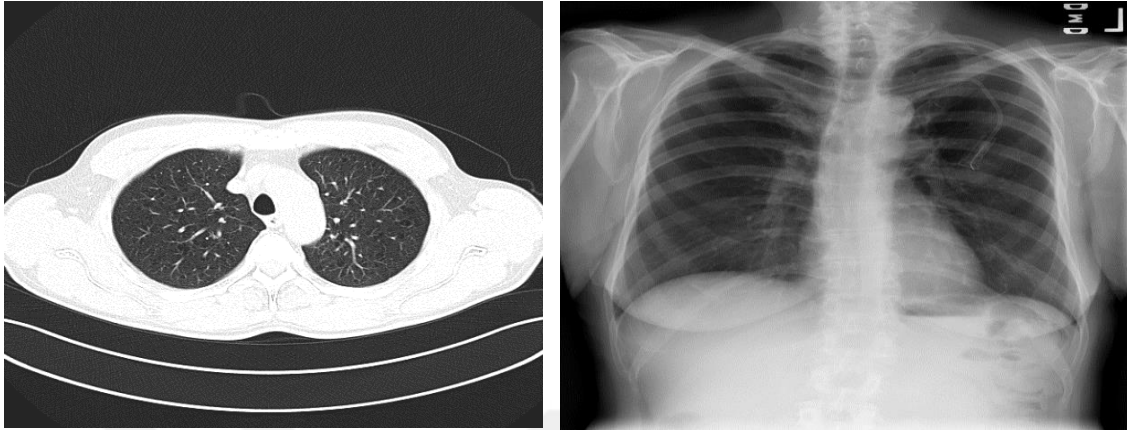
Chest CT and X-ray images
